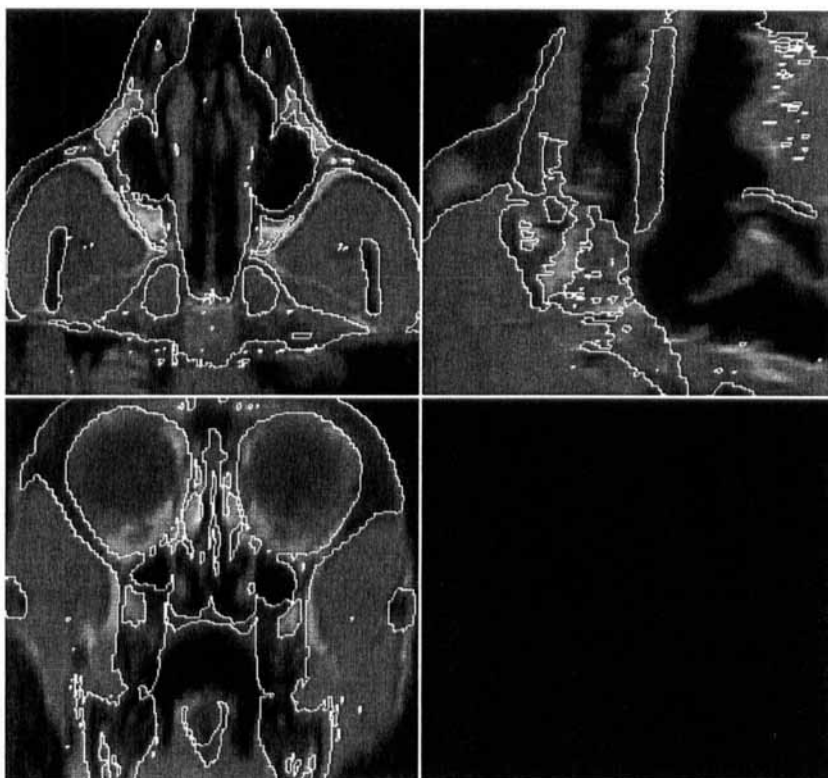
Orthogonal views from the MR, with the thresholded bone boundary from CT overlaid. Scan sequences described in the text.
